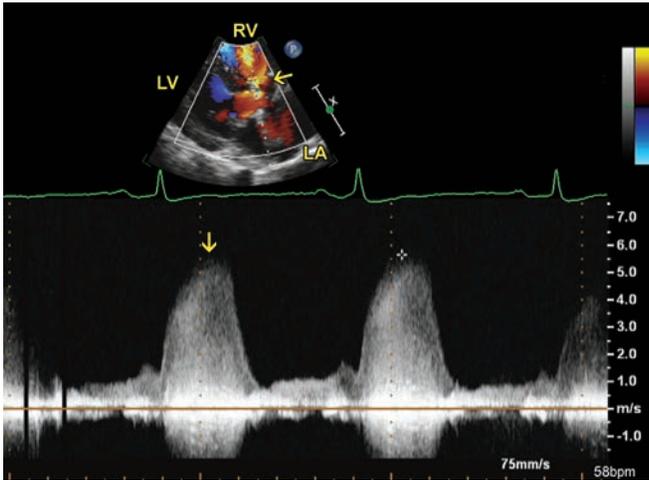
Pulsed wave Doppler to show maximum VSD velocity (arrow). This is utilized to calculate LV-RV gradient.
